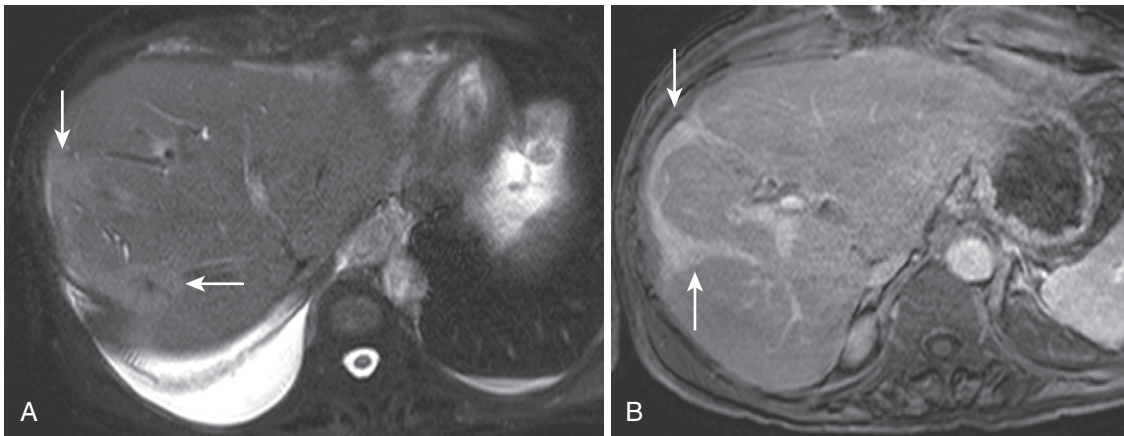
Confluent fibrosis. Two adjacent, peripheral, wedge-shaped lesions (*arrows*) with capsular retraction exhibit hyperintensity on the T2-weighted, fat-suppressed image (A) and delayed enhancement on the corresponding interstitial phase T1-weighted image (B).
